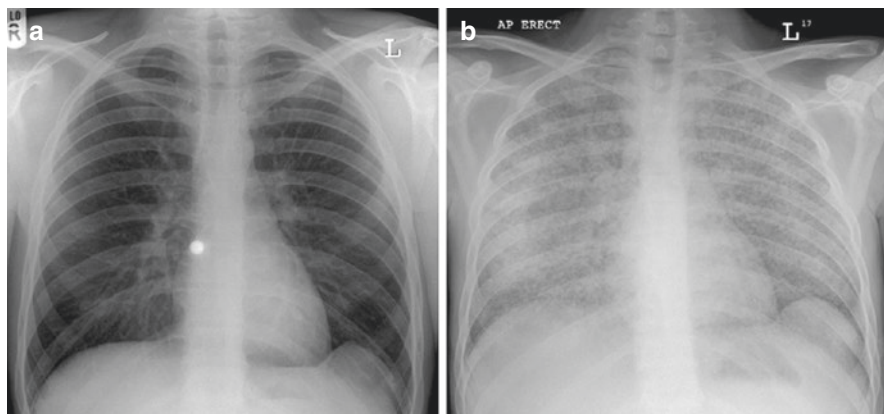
Chest radiograph showing miliary TB presenting in a renal patient with a PUO not immediately obvious on original radiograph (a), apparent on chest radiograph after two weeks (b)
